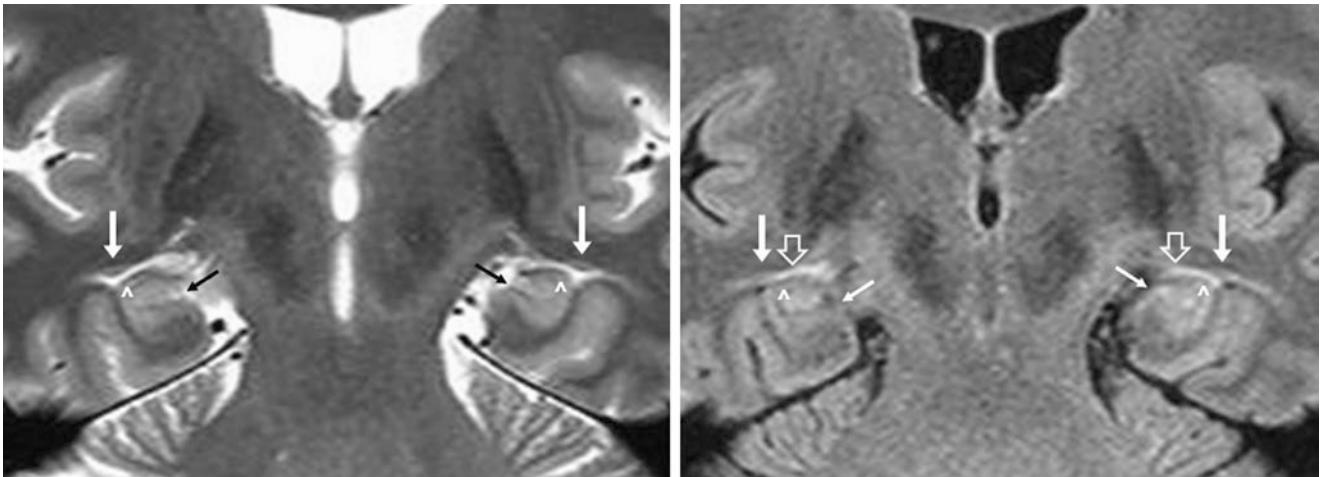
A 30 year old with seizures; on a negative 3 T MRI, a coronal T2WI (*left*) delineates both caudate tails (*arrows*), which are also visualized on a coronal FLAIR image (*right*). Note the hippocampi/
